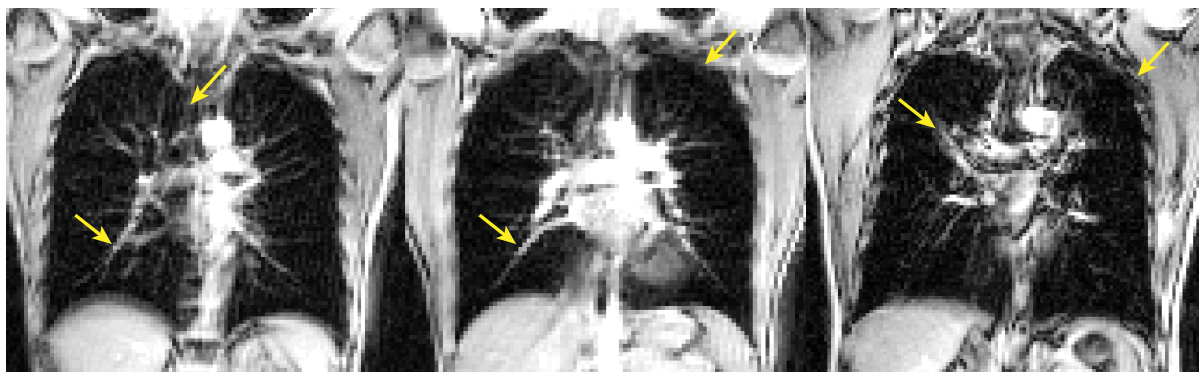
Pulmonary  $^1\text{H}$  MRI segmentation challenges. Centre coronal  $^1\text{H}$  MRI slices for three asthma participants with yellow arrows showing representative weak edges and protruding structures.
